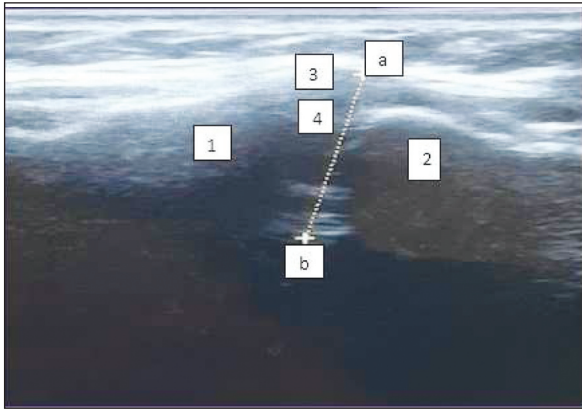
Ultrasonographic image of the width of the ACJ in the longitudinal plane in a healthy control. 1. Acromion; 2. Clavicle; 3. Joint capsule of the ACJ and superior acromioclavicular ligament; 4. Articular disc; a-b, the maximum distance between the joint capsule and deep joint space. ACJ: Acromioclavicular joint.
